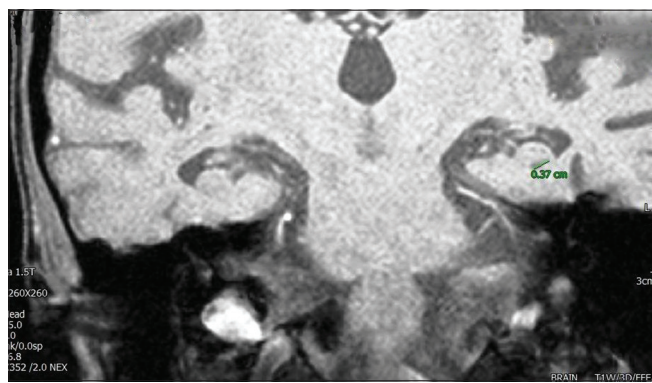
An HC with a diameter of 0.37 cm in the left hippocampus is noted in the T1-weighted image at the level of the hippocampus
